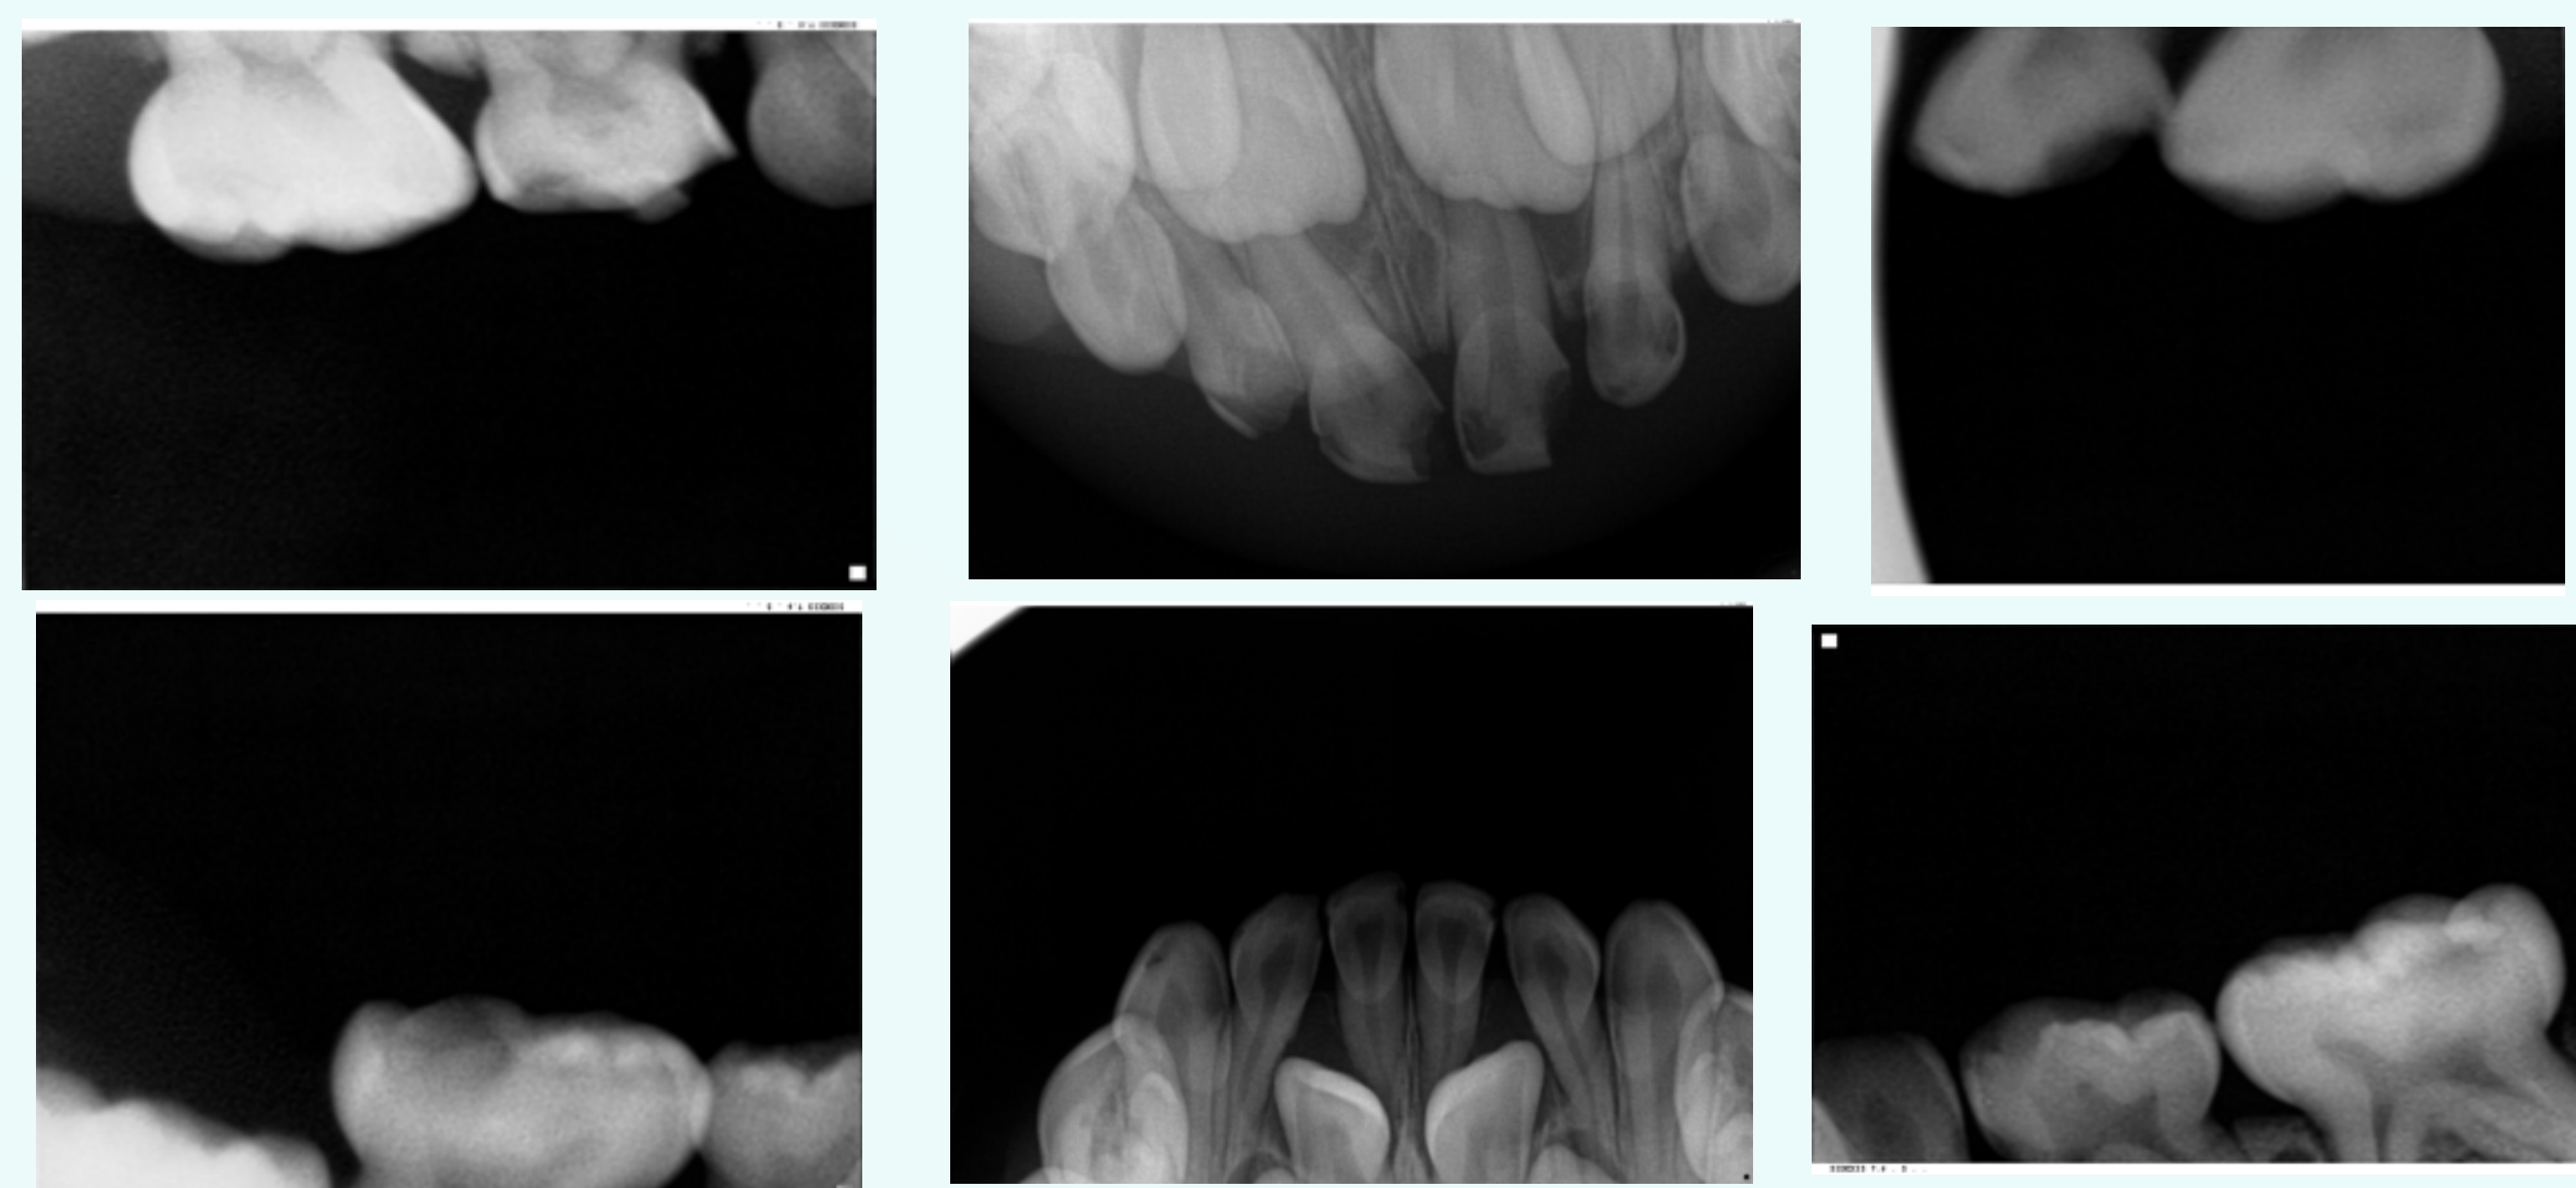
Xrays showing Severe Early Childhood Caries on 4y/o patient with Alagille Syndrome
